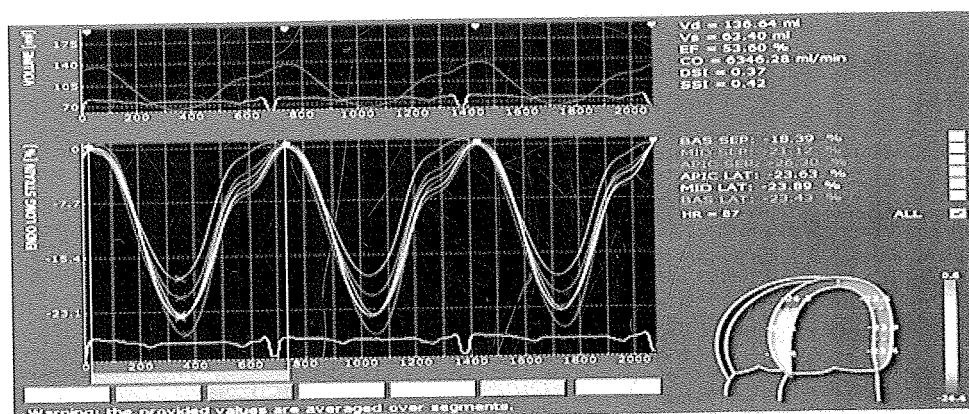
Strain echocardiography in a patient with normal angiography shows a relatively homogeneous pattern of peak systolic strains throughout the LV in the apical 4-chamber view
